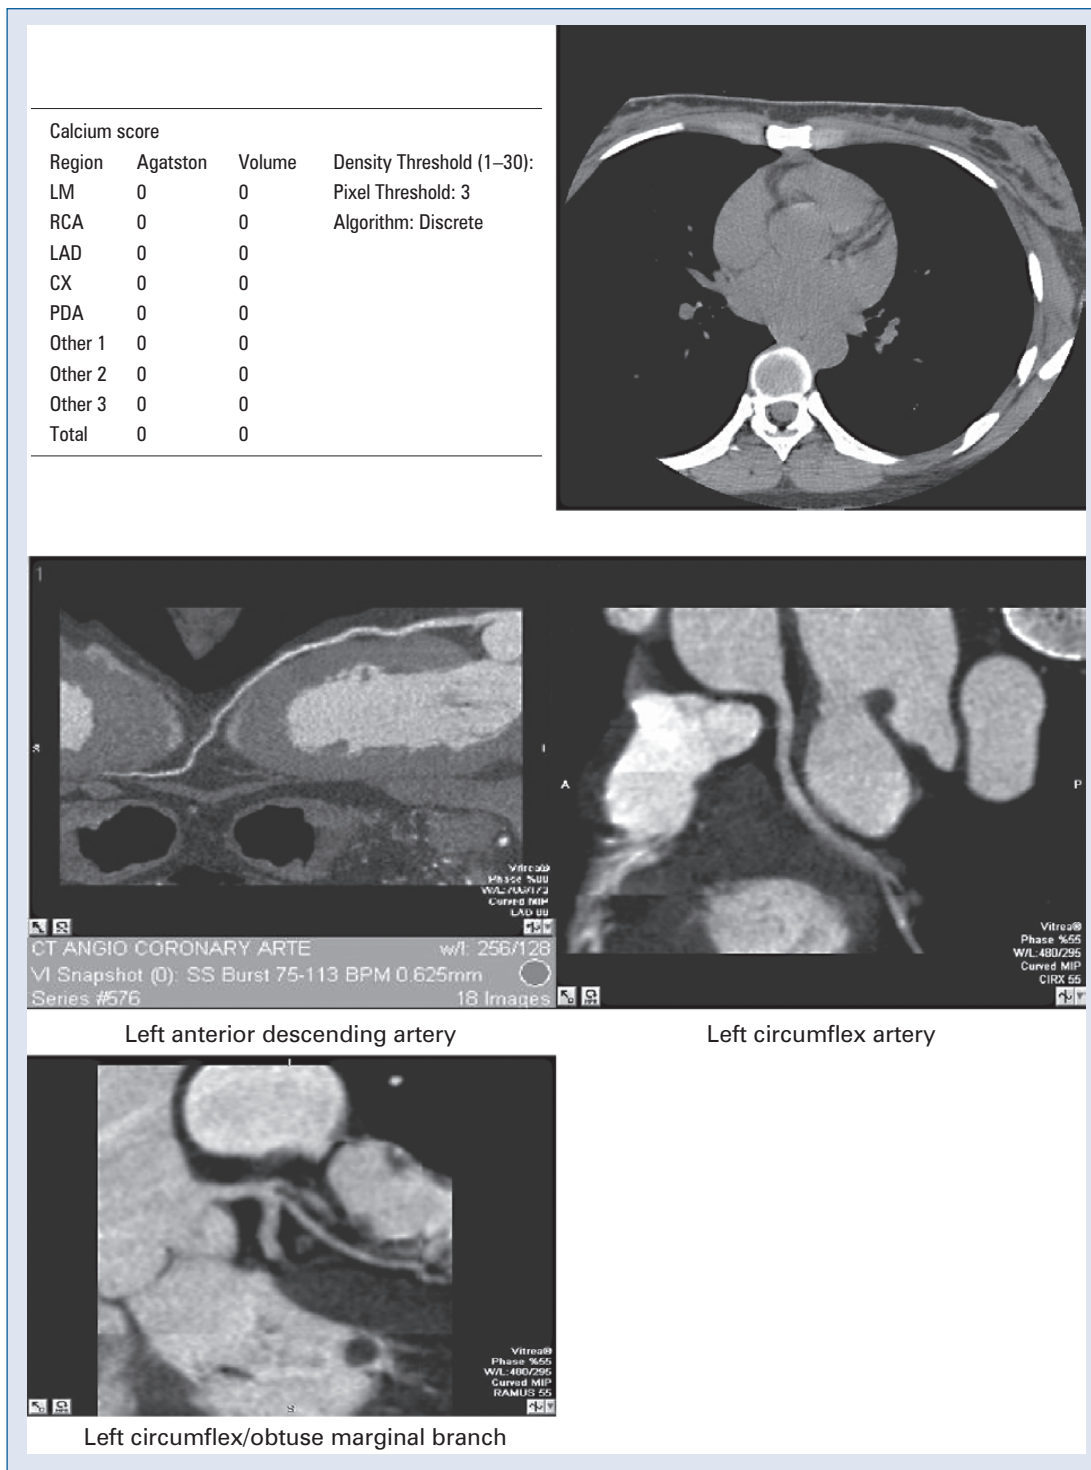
A. A 55 year-old patient on hemodialysis; submaximal dobutamine stress echocardiography requiring additional testing with stress myocardial perfusion scan. His research coronary computed tomography angiography (CCTA) is shown. As can be seen, there was no coronary calcium detected and no obstructive coronary artery disease documented and the CCTA was of diagnostic quality.
